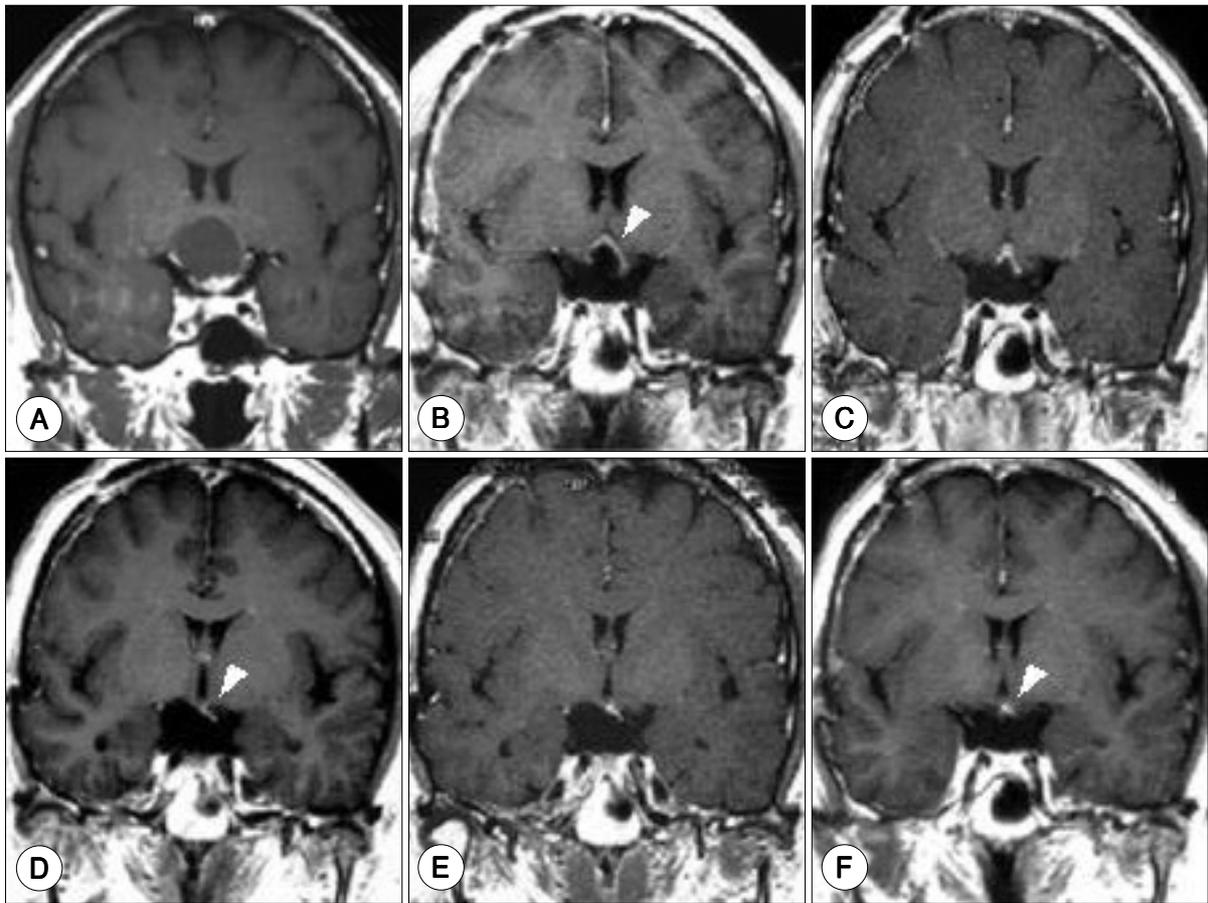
A : Preoperative MRI showing suprasellar craniopharyngioma. B : Postoperative and pre-radiosurgical MRI showing residual tumor near hypothalamus and optic pathway. C-F : Serial follow-up MRI (4, 13, 24, and 35 months after Gamma Knife radiosurgery, respectively) showing gradually decreased tumor remnant.
